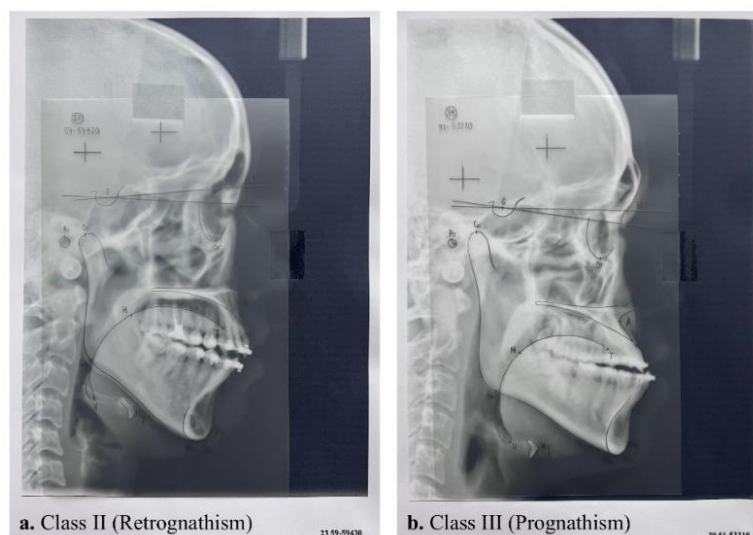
The examples of cephalometric radiographs tracing in 2 skeletal patterns;
